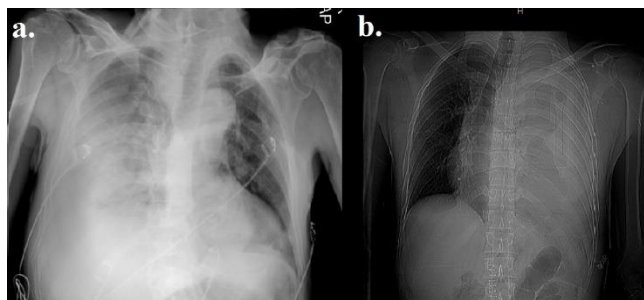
a) Chest radiography of patient 6 reveals right side hemothorax. b) Chest radiography of patient 9 reveals left side hemothorax.
